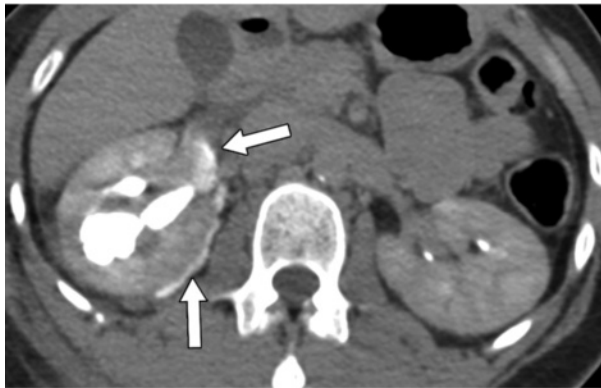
(10) Right ureteropelvic junction avulsion (grade V injury) in a 42-year-old woman who was involved in a motor vehicle accident. (a) Portal venous phase CT scan shows right hydronephrosis (\*) and a small amount of perinephric fluid near the renal hilum (arrow). (b) Delayed excretory phase CT scan helps confirm the presence of posteromedial urinary extravasation (arrows). The ureter distal to the point of injury was seen to be unenhanced. (11) Partial tear of the left ureteropelvic junction (grade V injury) in a 50-year-old woman who was involved in a motor vehicle accident. (a) Portal venous phase CT scan shows left hydronephrosis (\*) and a small amount of perinephric fluid (arrow). (b, c) Delayed excretory phase CT scans show medial perinephric urinary extravasation (arrow in b) and opacification of the distal ureter (arrowhead in c).
